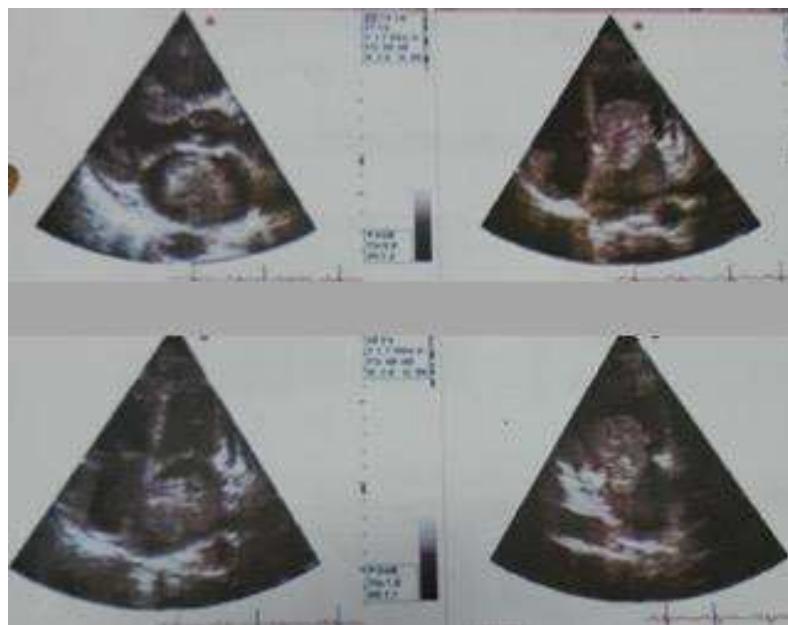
Initial echocardiogram reveals in left atrium a oval mass, pedunculated, adhered to the interatrial septum measuring 3.4 x 3.6 cm.
